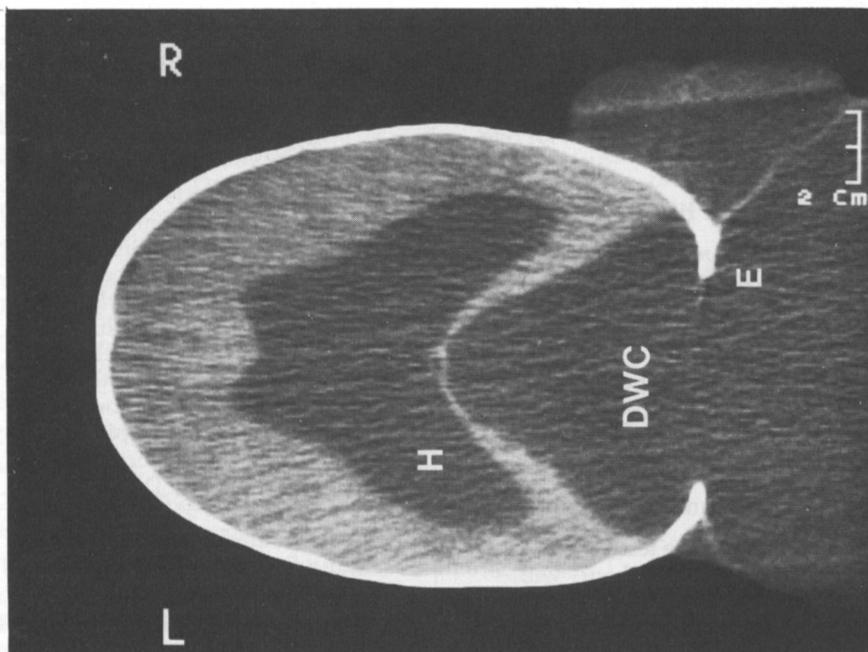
A CT brain scan of a baby with a Dandy-Walker cyst (DWC) opening into a large encephalocele (E) herniating through a defect in the back of the skull. The dilated lateral ventricles of the associated hydrocephalus (H) can also be seen.
